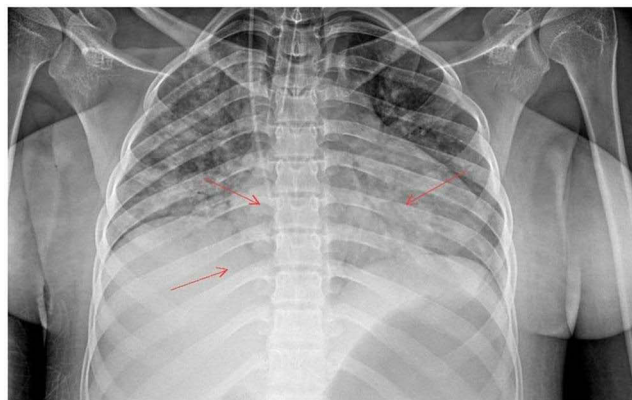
Admission chest radiograph: mild cardiomegaly, bilateral pulmonary opacities, and vascular congestion consistent with pulmonary edema. The red arrows indicate the bilateral perihilar and basal pulmonary opacities with vascular congestion that are consistent with pulmonary edema.
